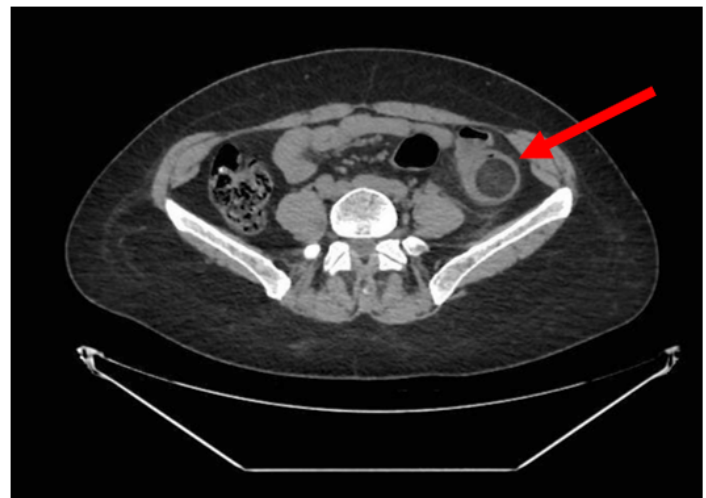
Abdominal CT scan (axial section) with findings of colonic intussusception.
